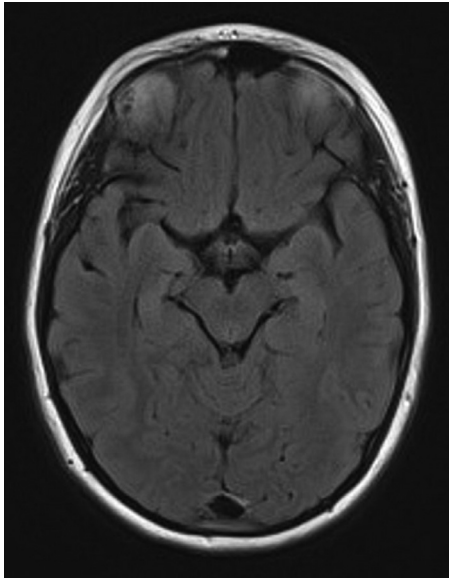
Posttreatment axial FLAIR MRI brain demonstrating a total resolution of the subcortical white matter signal abnormality.
